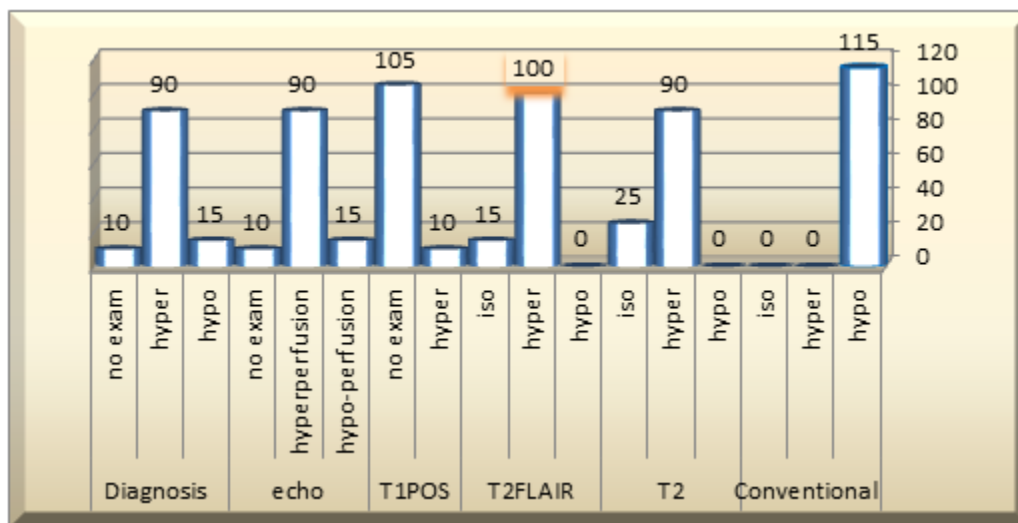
The figure above indicates Conventional protocol diagnosis imaging hyper signal intensity T2 FLAIR (115) cases in the conventional protocol C, while the technique T1 WI-SE post contrasts no exam (105) cases . Regarding technique T2 FLAIR hyper SI(100) cases
